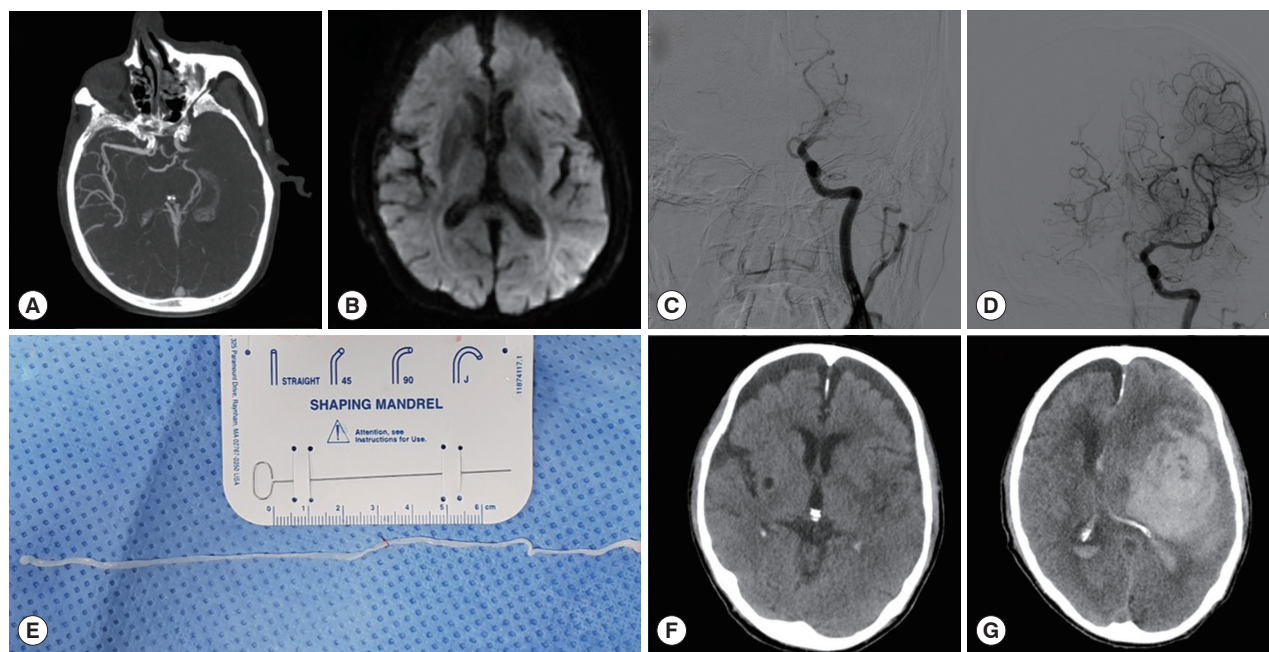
Findings of an 89-year-old male with acute ischemic stroke. (A) Initial supra-aortic CT angiography showing acute occlusion of left middle cerebral artery. (B) Subsequent diffusion-weighted imaging at same day. (C) Initial left carotid angiography for endovascular mechanical thrombectomy. (D) Partial reperfusion of occluded artery was achieved. (E) One whitish long worm with sluggish movement. (F) Follow-up brain CT image at day 1. (G) After neurological worsening, a follow-up brain CT image showing massive parenchymal hematoma on the affected hemisphere.
